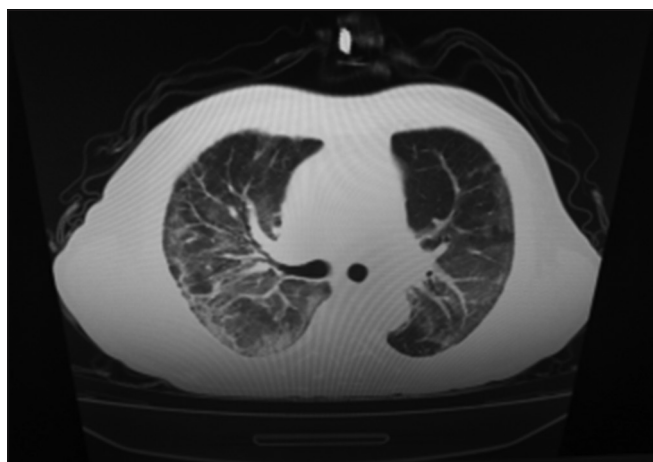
Chest computed tomography image of the patient before discharge (March 13)
